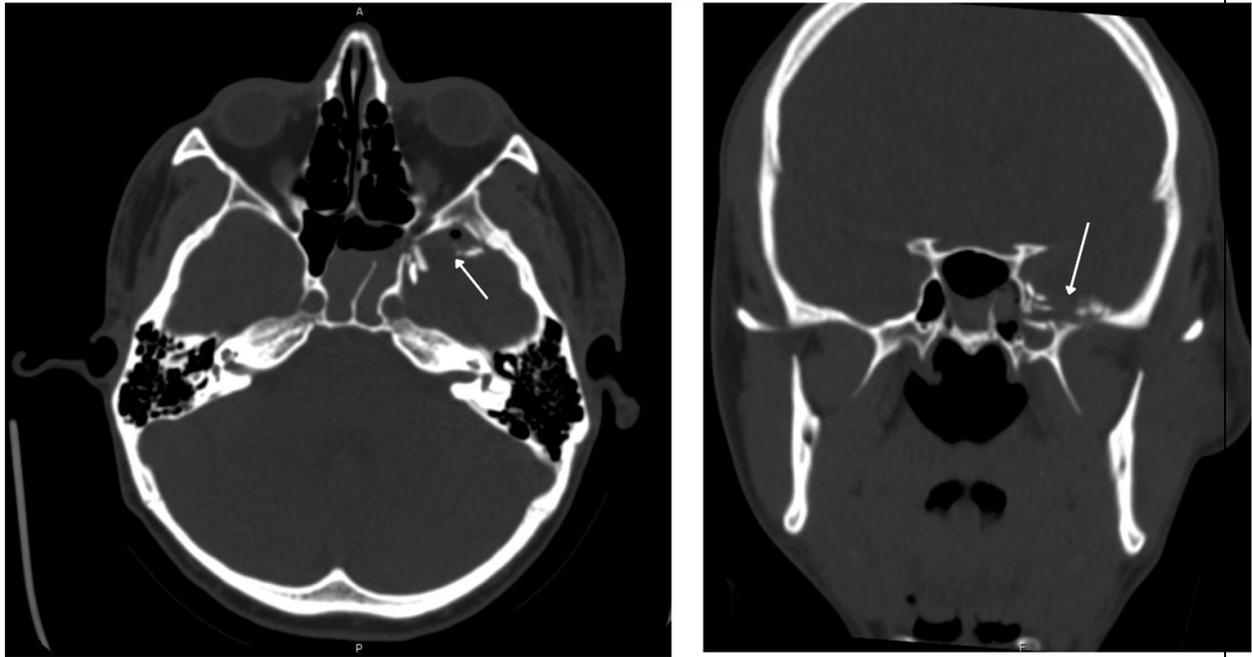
Axial and coronal CT images of the patient's head showing small air and comminuted fractures of the anterior sphenoid bone. The white arrows show bone fragments in the superior orbital fissure.
